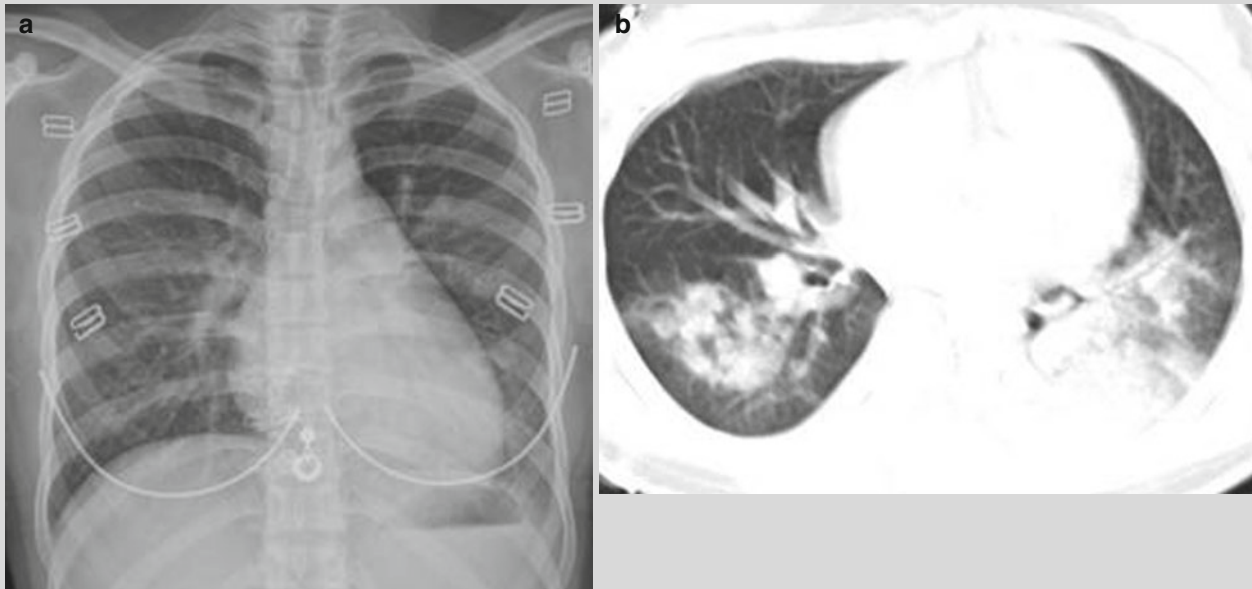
Anterior-posterior chest x-ray 1 day after onset showed increased and thickened lung markings; small ground glass opacity in the left upper lung (a). Chest CT on d 3 after onset showed multiple patchy and nodular consolidations in both lungs, predominantly in the lower lung (b). Re-examination CT scan on d 5 after onset showed progression of the lesions into large consolidation, with air bronchogram inside (c). Re-examination after anti-viral
